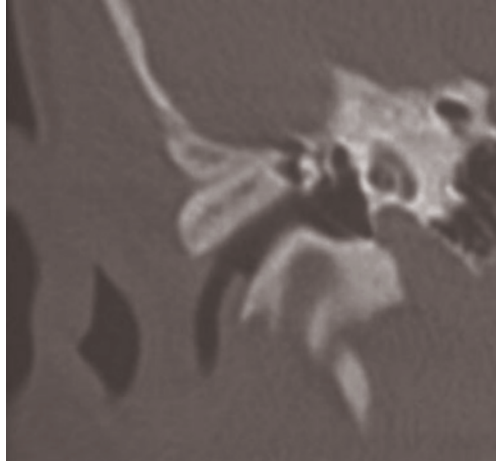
Coronal CT scan. Abnormal angulation of the external auditory canal.
